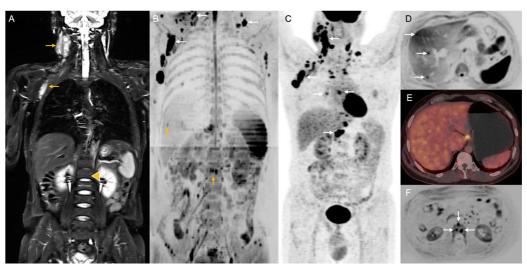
Stage IV on both WB-MRI and PET-CT. A. Coronal STIR image showing STIR hyperintense enlarged cervical and axillary lymph nodes (yellow arrows). B. Coronal MIP DWI images showing multiple enlarged diffusion-restricting lymph nodes in the cervical and axillary regions (white arrows). Multiple small diffusion-restricting lesions are also seen in the L1 vertebra and Liver (yellow arrows). The vertebral lesions are not detectable on the STIR (yellow arrowhead on A). C. Coronal PET MIP image showing multiple FDG avid lesions in the cervical, axillary, mediastinal, hilar and periportal nodes (yellow). However, the vertebral lesions and liver lesions which were better seen on DWI images are not seen. D. Axial DWI image showing multiple small diffusion-restricting lesions (white arrows) in the right lobe of the liver. E. Axial PET-CT image at the corresponding level does not show any FDG avid lesions. F. Axial DWI image showing multiple vertebral lesions (white arrows) involving the L1 vertebral body.
